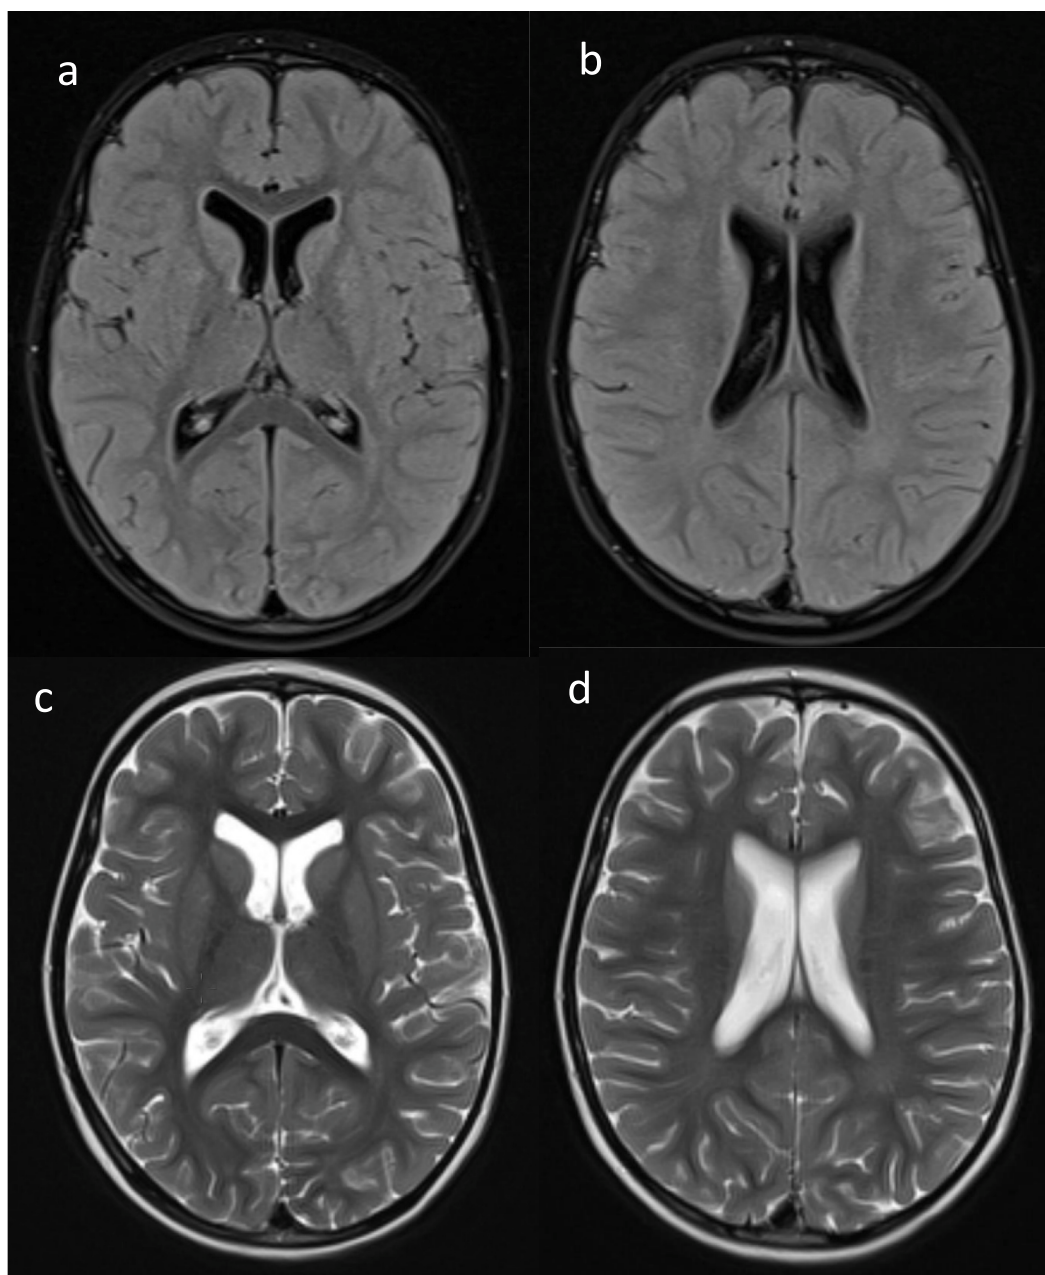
Patient 2. Follow-up MR examination at the age of 3.5 years. Axial FLAIR (a, b) and T2-weighted (c, d) images revealed complete regression.
